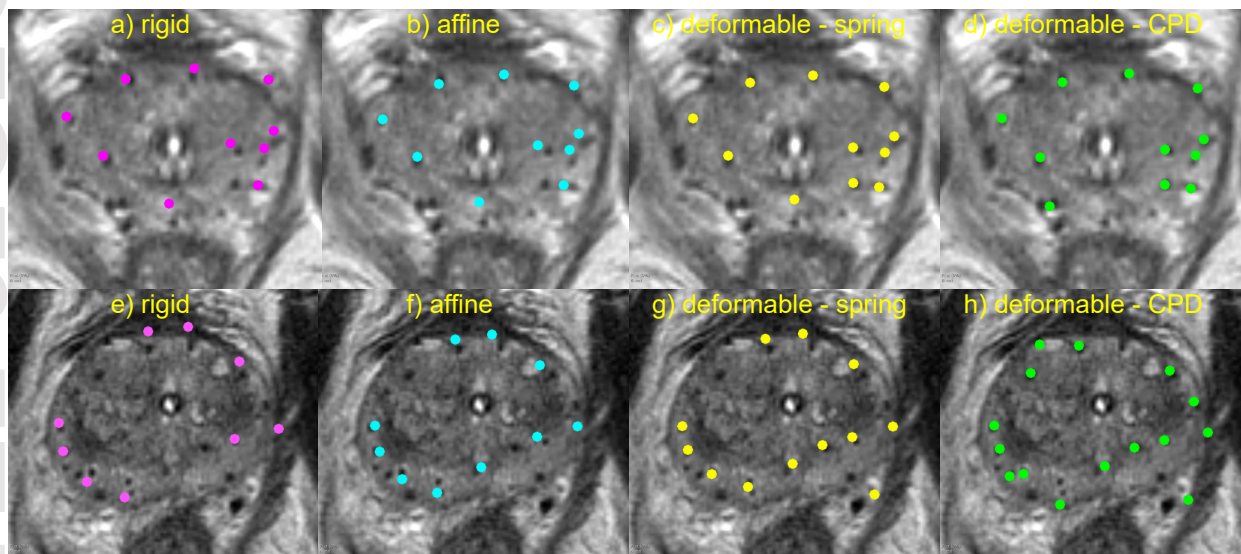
Example MR images with registered X-ray-based seed locations from two patients.
